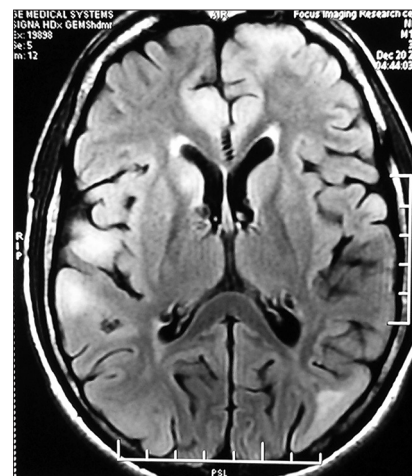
MRI scan showing calcified nodules and subependymal tubers on T1 weighted images
